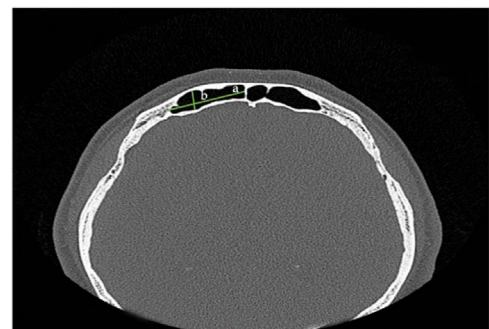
Axial CT scan shows the right frontal sinus width (a) and the right frontal sinus anteroposterior length (b).
